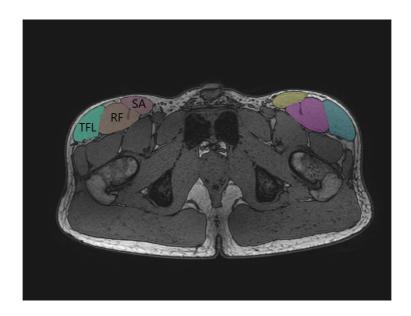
Axial MR images tensor fascia latae (TFL), Rectus Femoris (RF), Sartorius (SA).
